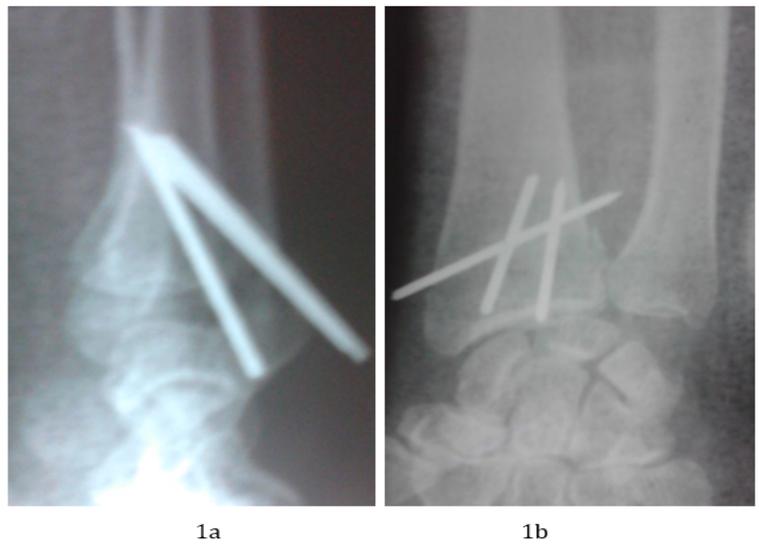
Immediate radiographic control of the face and profile of the wrist.
